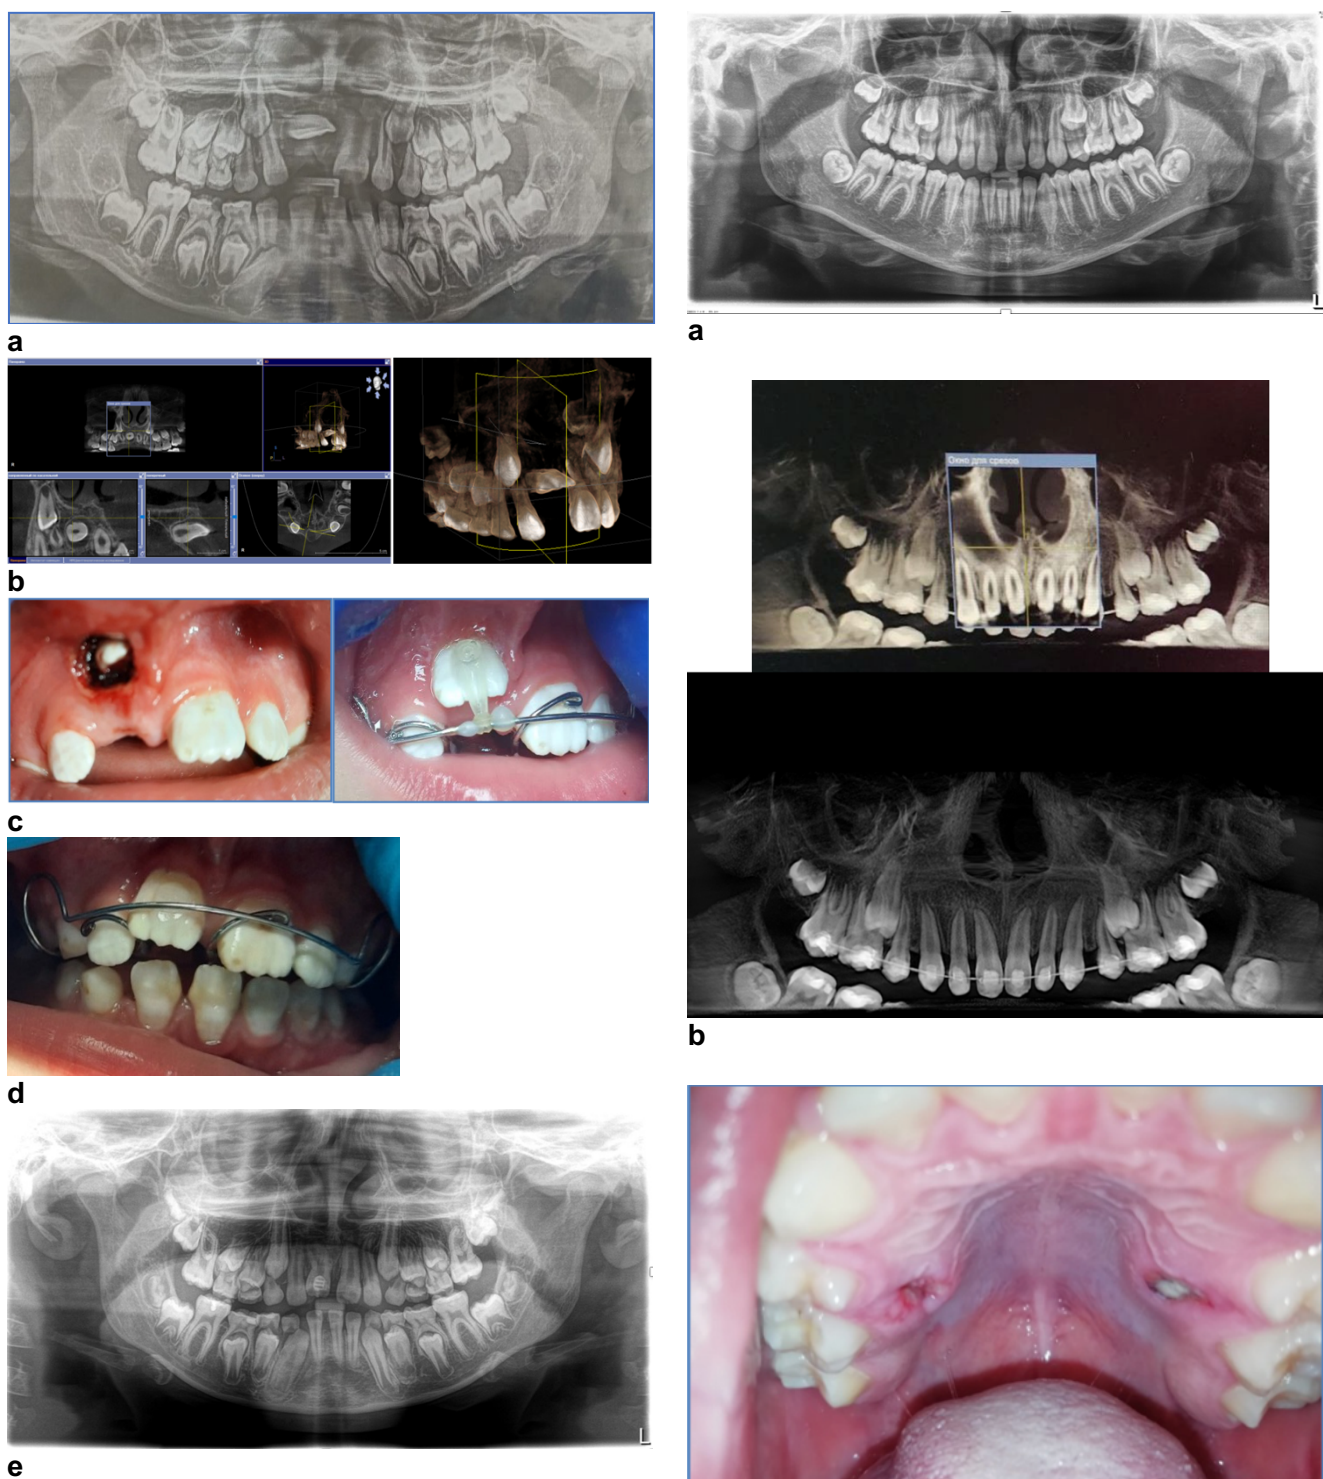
Patient X.: (a) orthopantomogram before treatment, (b) 3D computed tomography (dystopia and impaction of 11 tooth are indicated), (c) photo after surgery, (d) - 11 tooth in the process of orthodontic movement to dentition, (e) – orthopantomogram, taken at the stage of orthodontic treatment.
